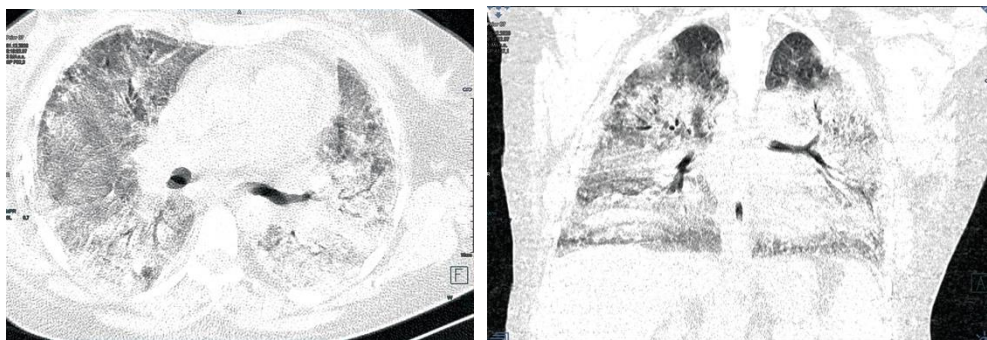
Computed tomography of the chest upon admission. Subtotal lung damage. The approximate volume of detected changes is more than 75%
